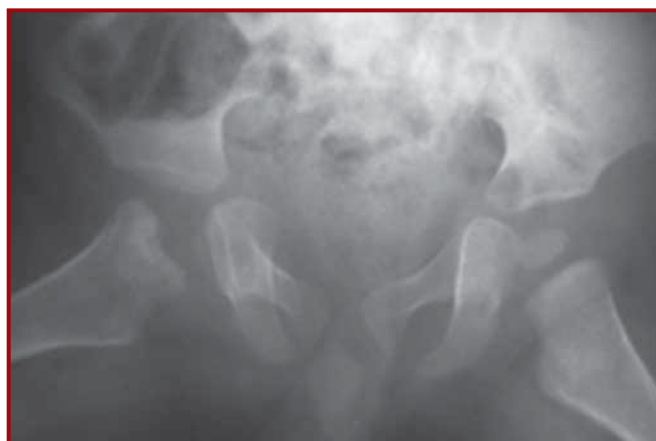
Six weeks after the operation, radiograph of the pelvis demonstrates deformed proximal femoral metaphysis and no visible femoral head on the right. Note the right hip is reduced
